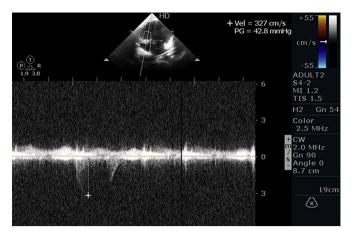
TTE with CW Doppler showed presence PHT with TR jet of 42 mm of Hg.
